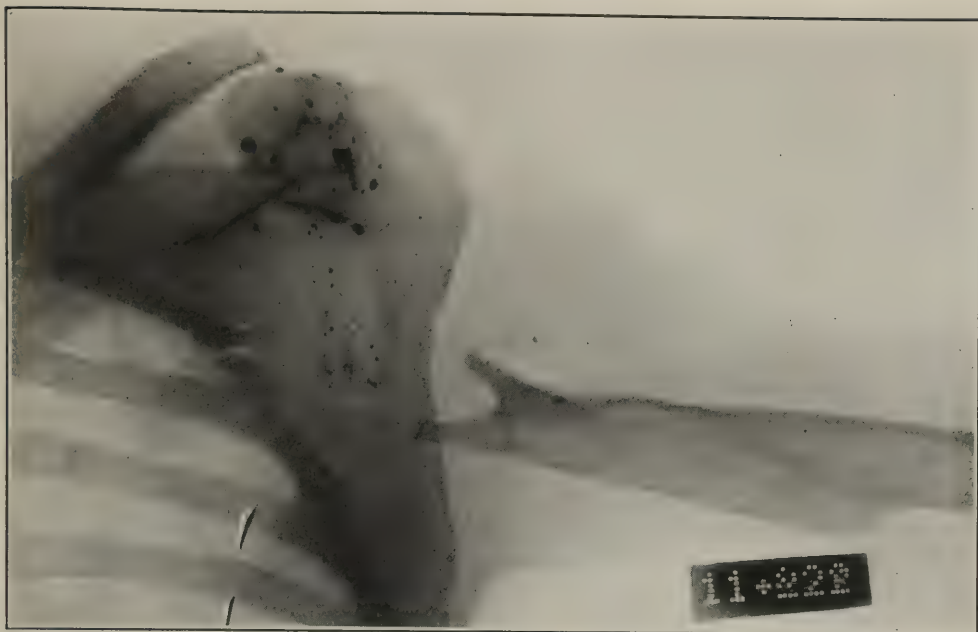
Case 7. Roentgenogram before operation, showing loss of substance
